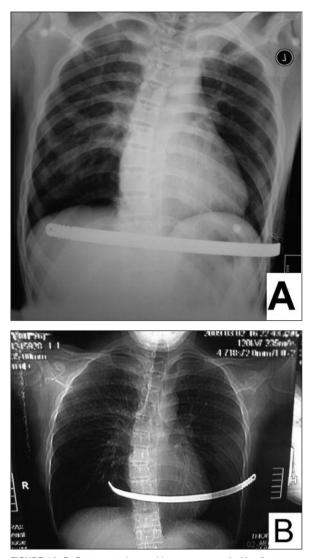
Posteroanterior graphic appearances. A: After first operation, B: Before second operation. Being absorbable, the stabilizer is not visible in the x-ray.
